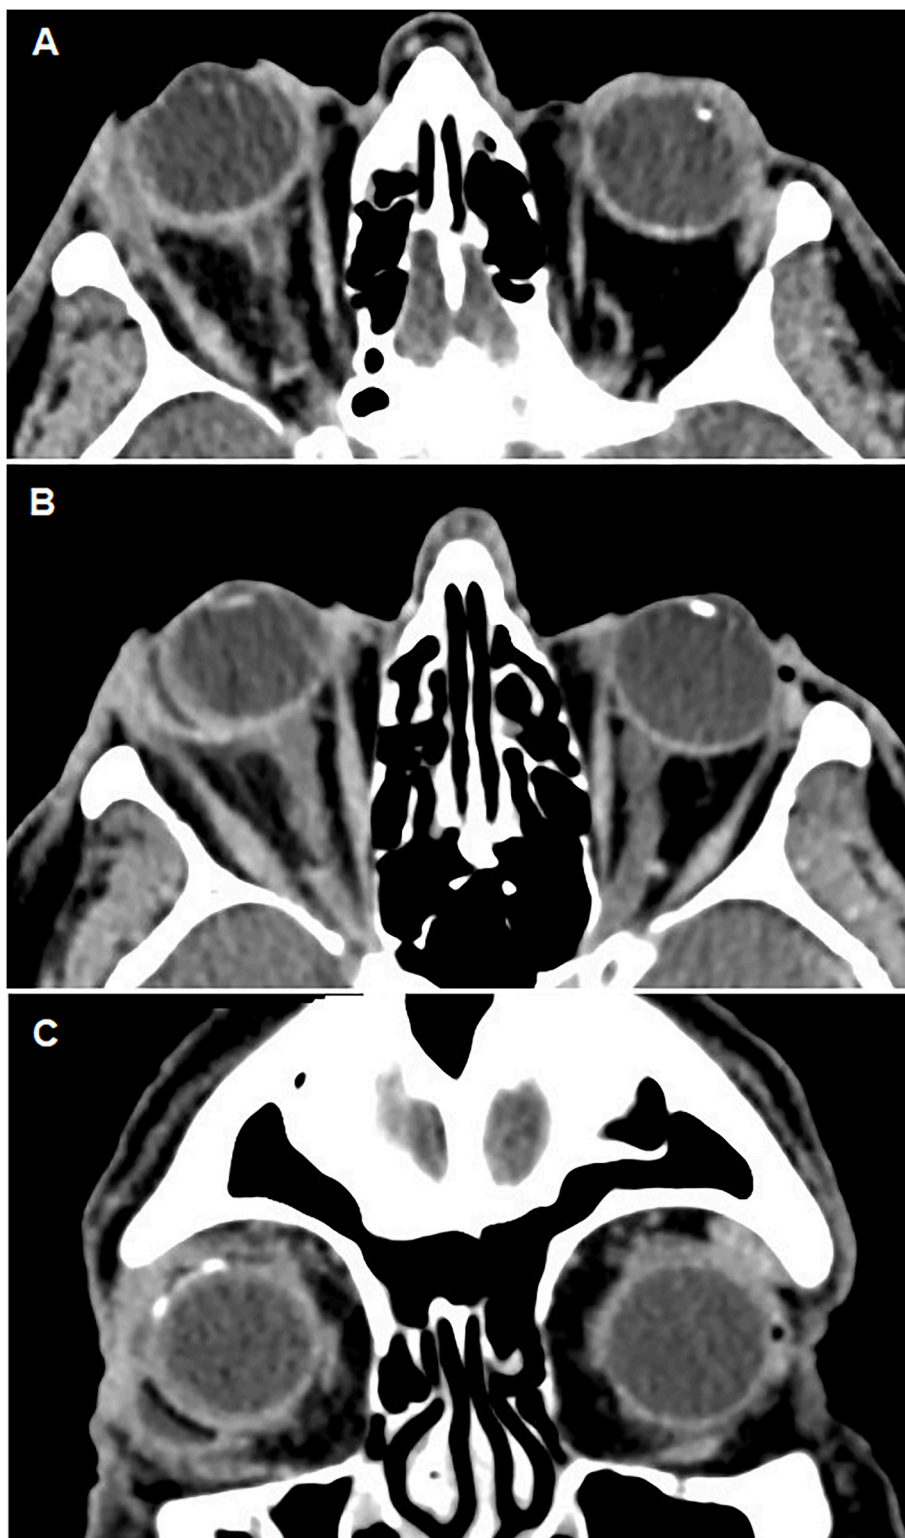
Contrast-enhanced computed tomography (CT) of the orbits demonstrates radiographic evidence of orbital cellulitis including right proptosis, scleral thickening and enhancement of lateral rectus along tendinous insertion (A, B). Coronal view of superotemporal and inferotemporal glaucoma drainage devices in the right globe with heterogenous fluid collection overlying inferotemporal glaucoma drainage device (C).
